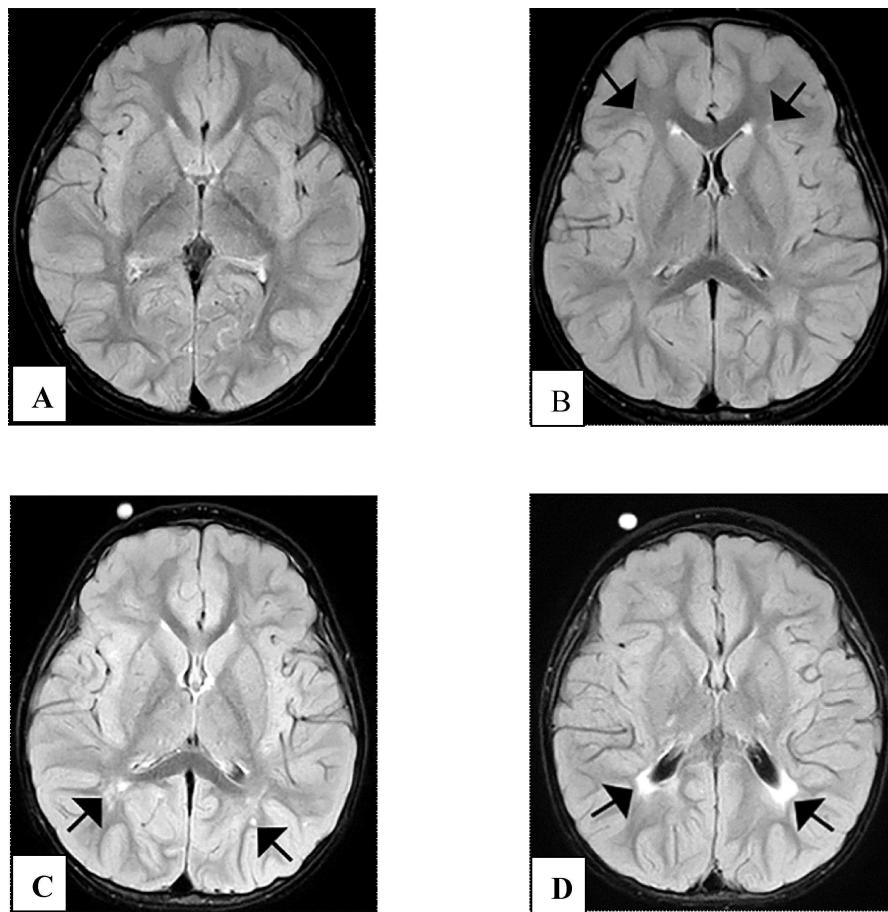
Grading of white matter signal abnormalities: WMSA (arrow) on T2 FLAIR, Grade 1: No WM abnormality (A), Grade 2: Less than or equal to 5 punctate lesions (B), Grade 3: More than 5 punctate lesions (C), Grade 4: Patchy confluent lesions or extensive white matter signal change (D).
